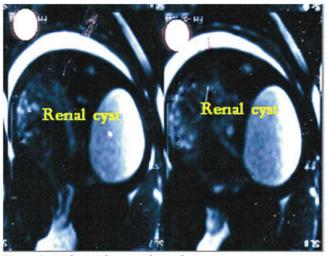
Fetal MRI shows single renal cyst.
